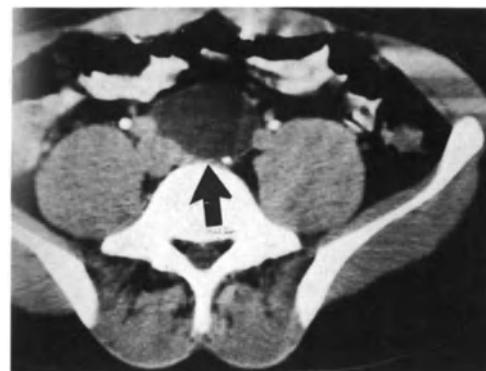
CT scan of the pelvis. The patient has a teratoma and has had treatment. A previously solid node has become cystic (arrow).
